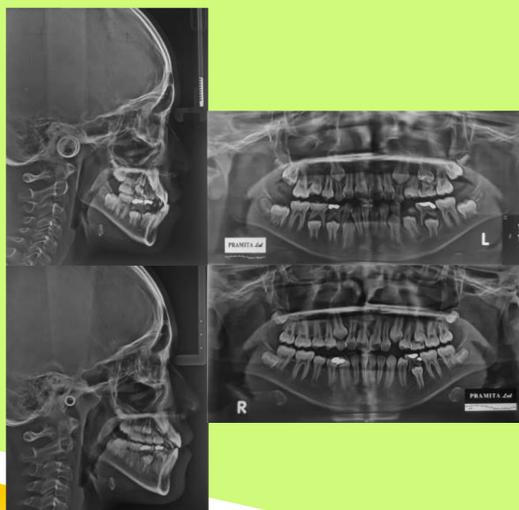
Radiograph pretreatment (above) and posttreatment (below)
